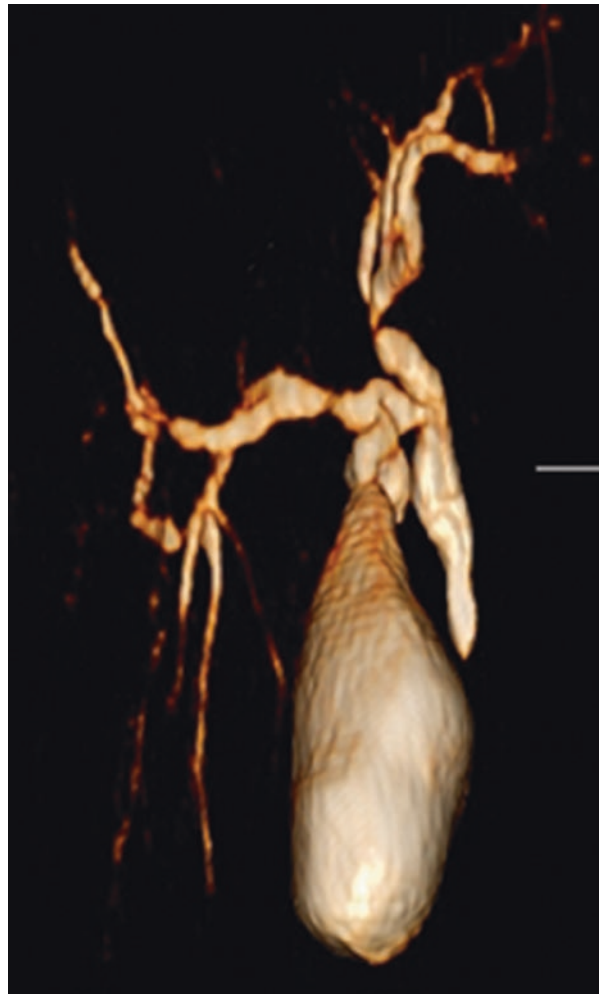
3D reformatted image of a CT cholangiogram showing the common bile duct and intrahepatic biliary ducts
